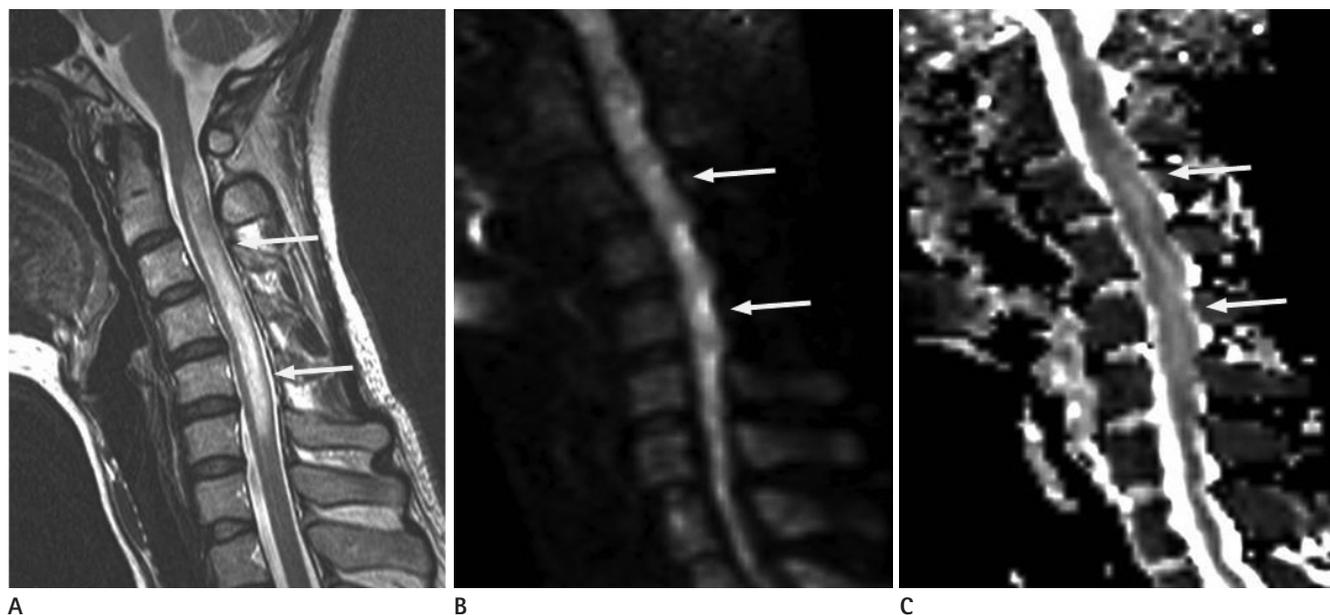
A 29-year-old woman with acute transverse myelitis. MRI taken 5 days after onset of symptoms.
